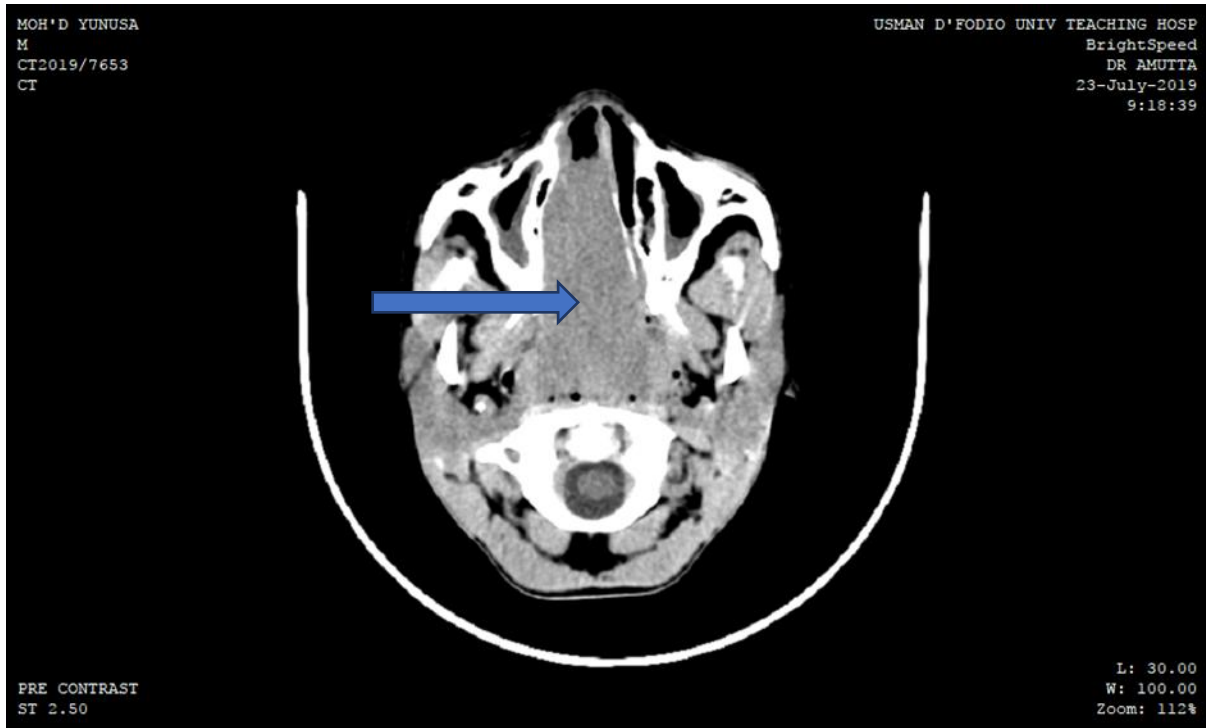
Pre-contrast CT scan of the paranasal sinuses showing a huge isodense mass (blue arrow) in the nasopharynx and nasal right nasal cavity.
